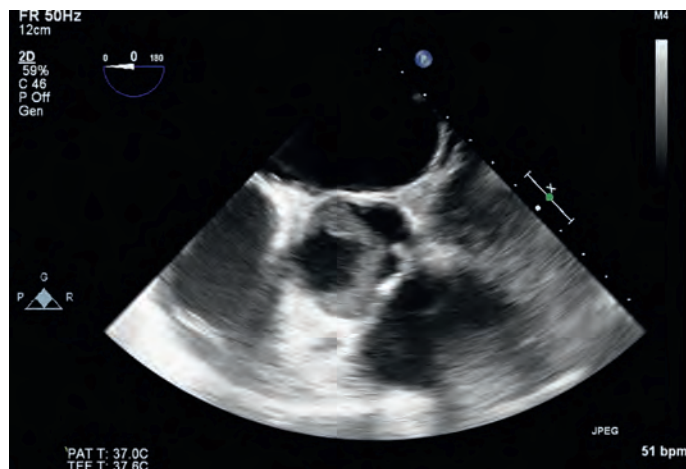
Aortic dissection with demonstration of the true versus false lumen. Left, Type A aortic dissection. The larger false lumen is seen on the left of the screen containing thrombus. Right, Superimposition of color-flow Doppler demonstrating flow in the true lumen during systole.
